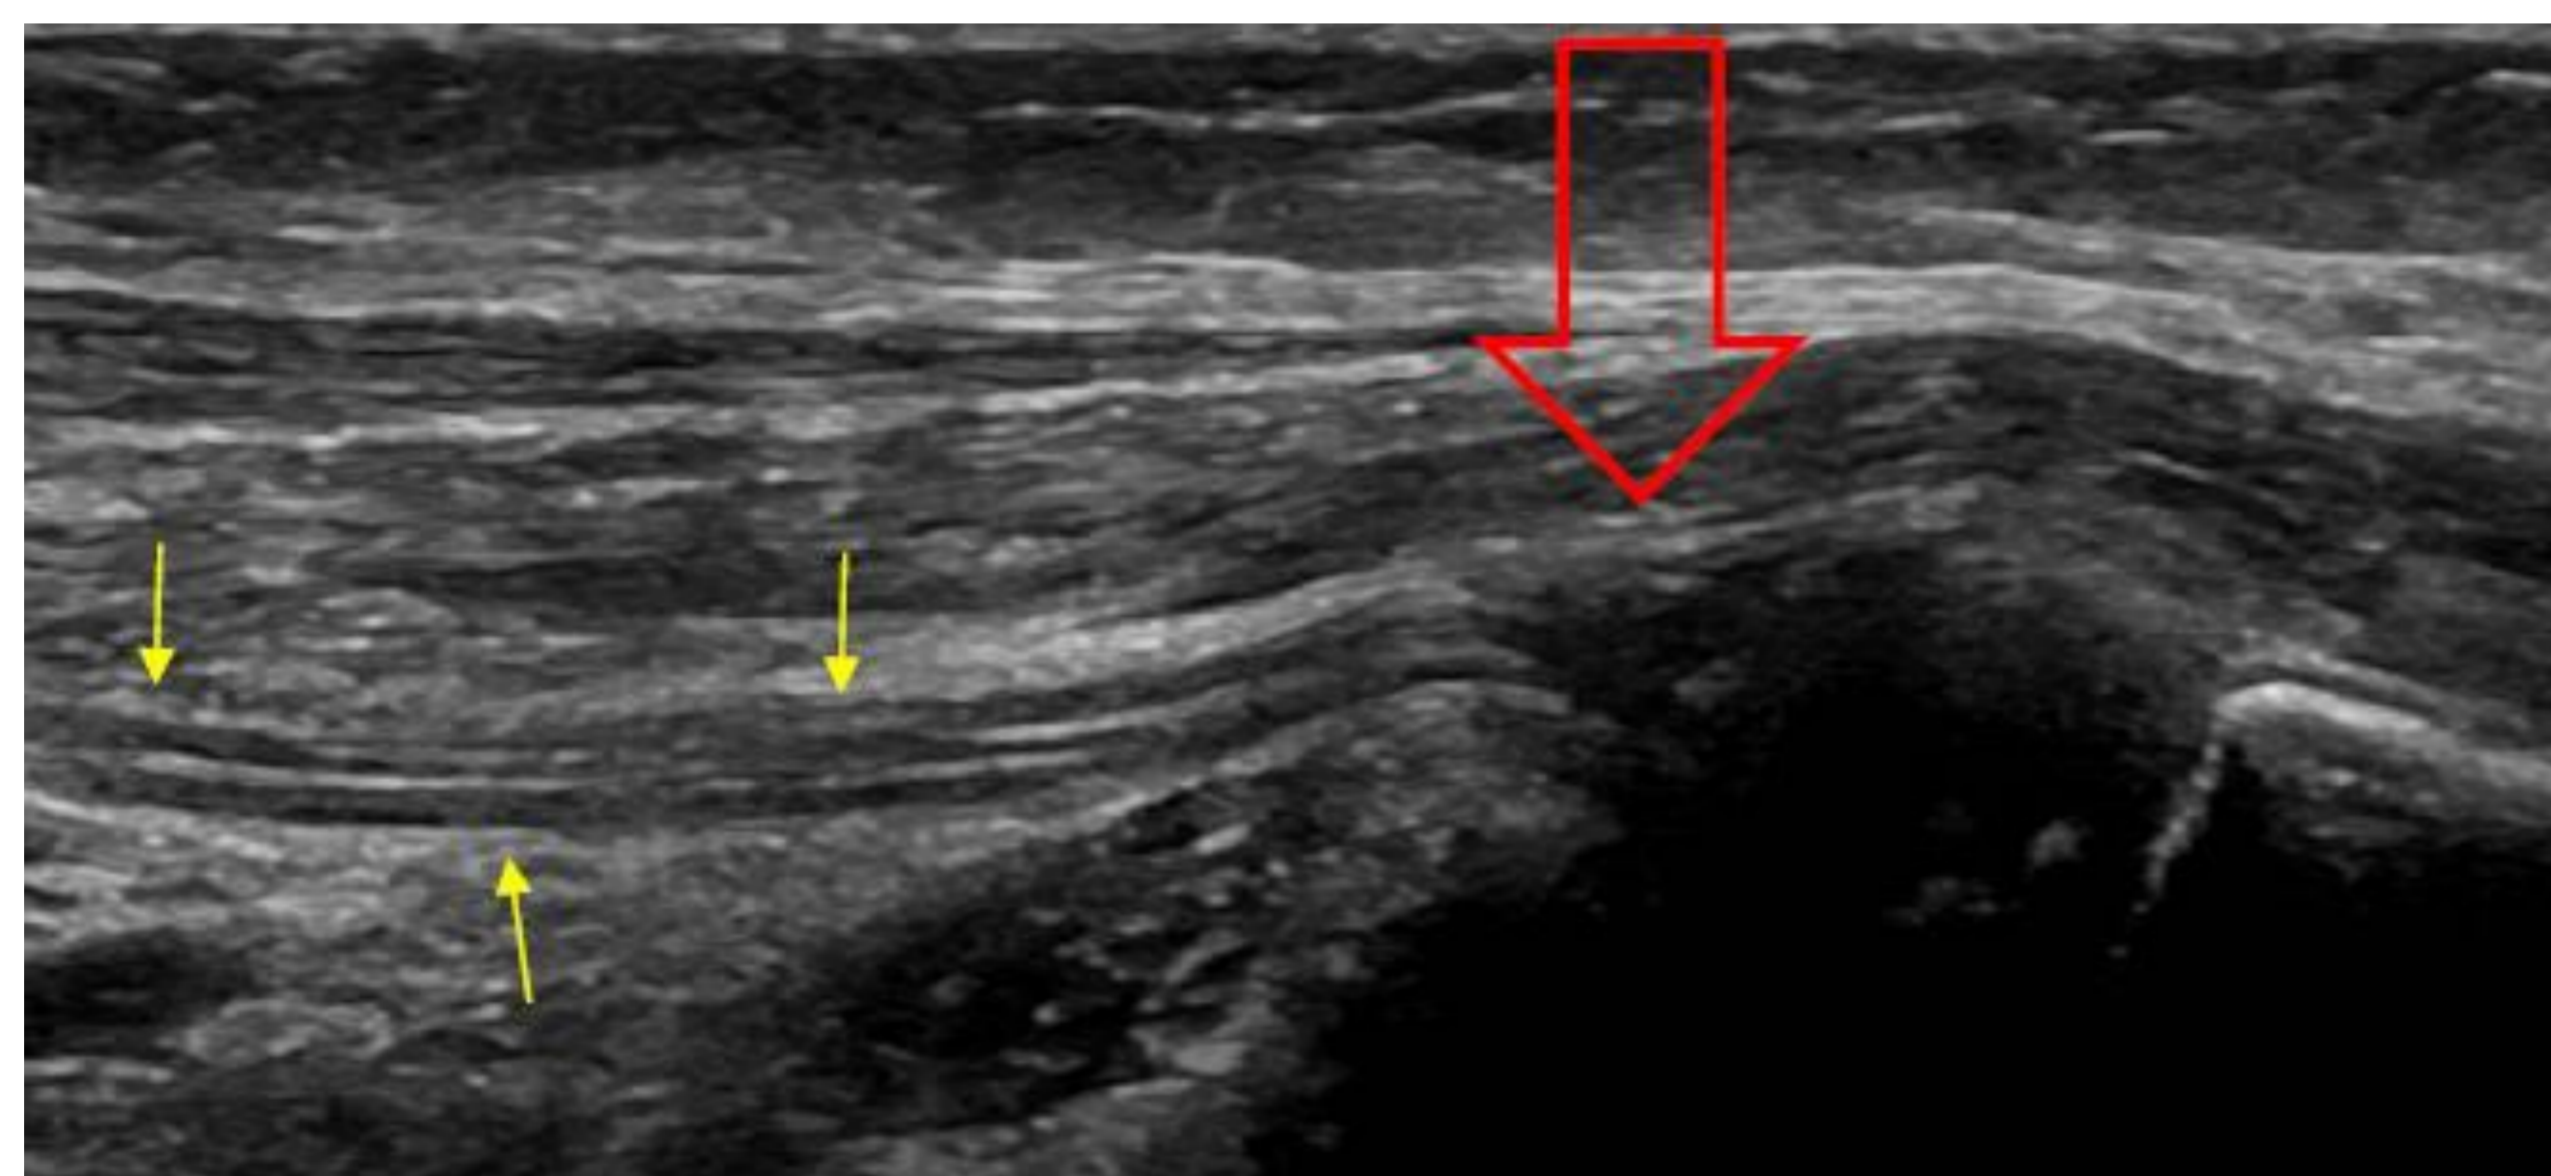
Ultrasound of the median nerve at the elbow. The nerve is observed normal distal to the joint (yellow arrows). At the level of the joint the nerve disappears (red arrow).
